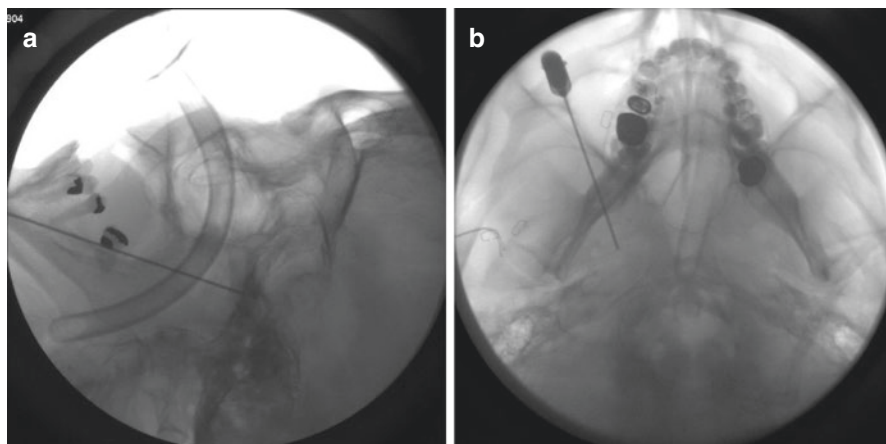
Radiographic localization of foramen ovale. Lateral (a) and submental vertex (b) XR views demonstrate appropriate needle placement at the skull base. Overlapping of the clivus and planum sphenoidale is evident in the lateral view (a)
